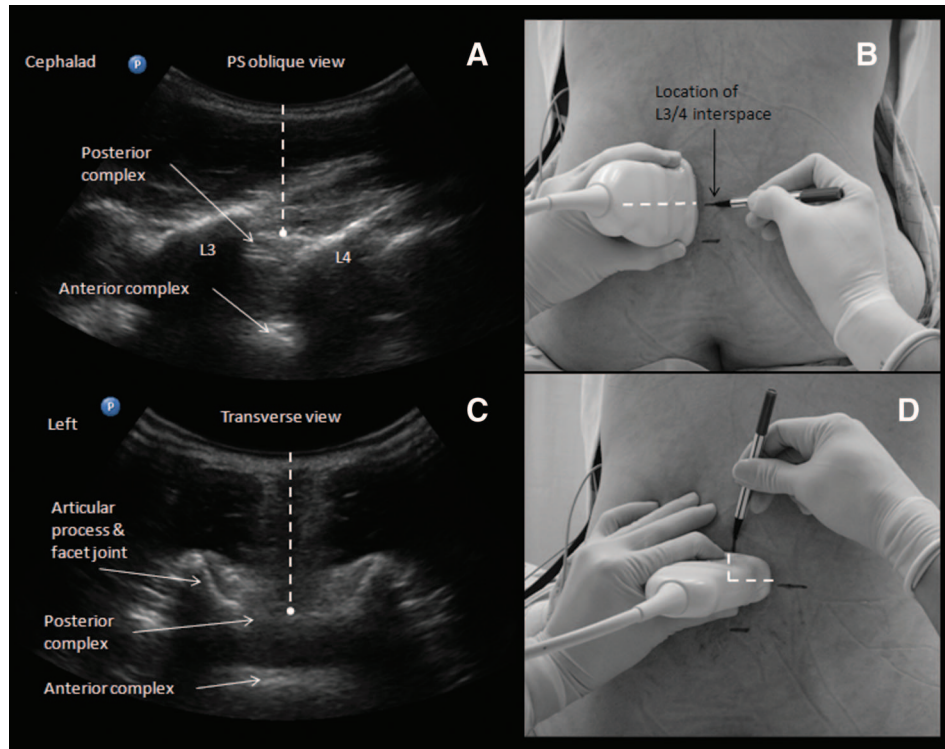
Surface marking to guide needle insertion. In the paramedian sagittal (PS) oblique view, each interspace (L3–L4 in this case) is centered in turn on the ultrasound screen (A). A corresponding skin mark is made at the midpoint of the probe's long edge (B). The probe is then turned 90 degrees to obtain the transverse interlaminar view (C). The midline is centered on the ultrasound screen, and skin marks are made at the midpoint of the probe's long and short edges (D). The intersection of these two marks provides an appropriate needle insertion point for a midline approach to the epidural or intrathecal space at that level. (Image used with permission from www.usra.ca.)
